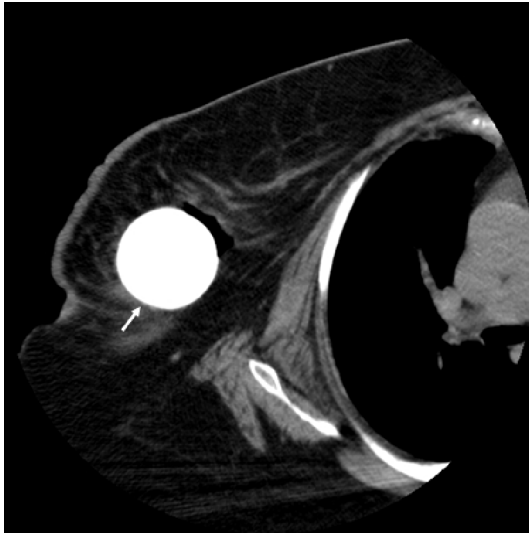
Post-operative CT scan of right breast. White arrow indicates brachytherapy balloon filled with normal saline.
